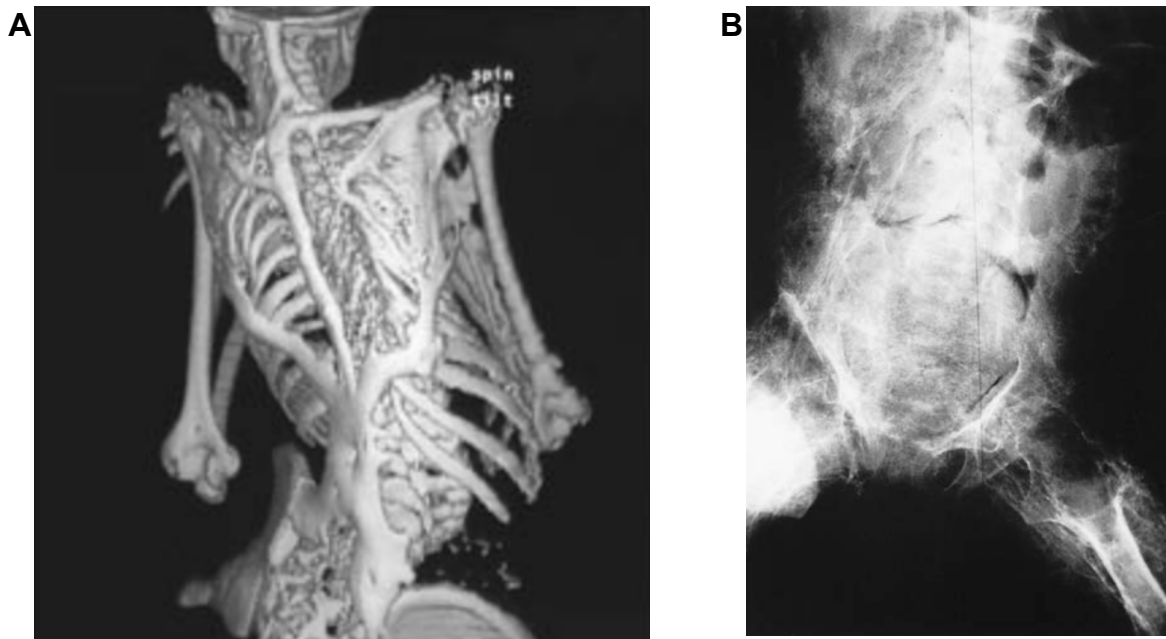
A) 3D computed tomographic reconstruction of the thorax, spine, and upper limbs of a 12 year old child with familial ossificans progressiva. Reproduced from Shore *et al.*¹⁶ B) Plain radiograph of the trunk and pelvis of a 20 month old child with progressive osseous heteroplasia. Reproduced with permission from Urtizberea *et al.*¹⁸
